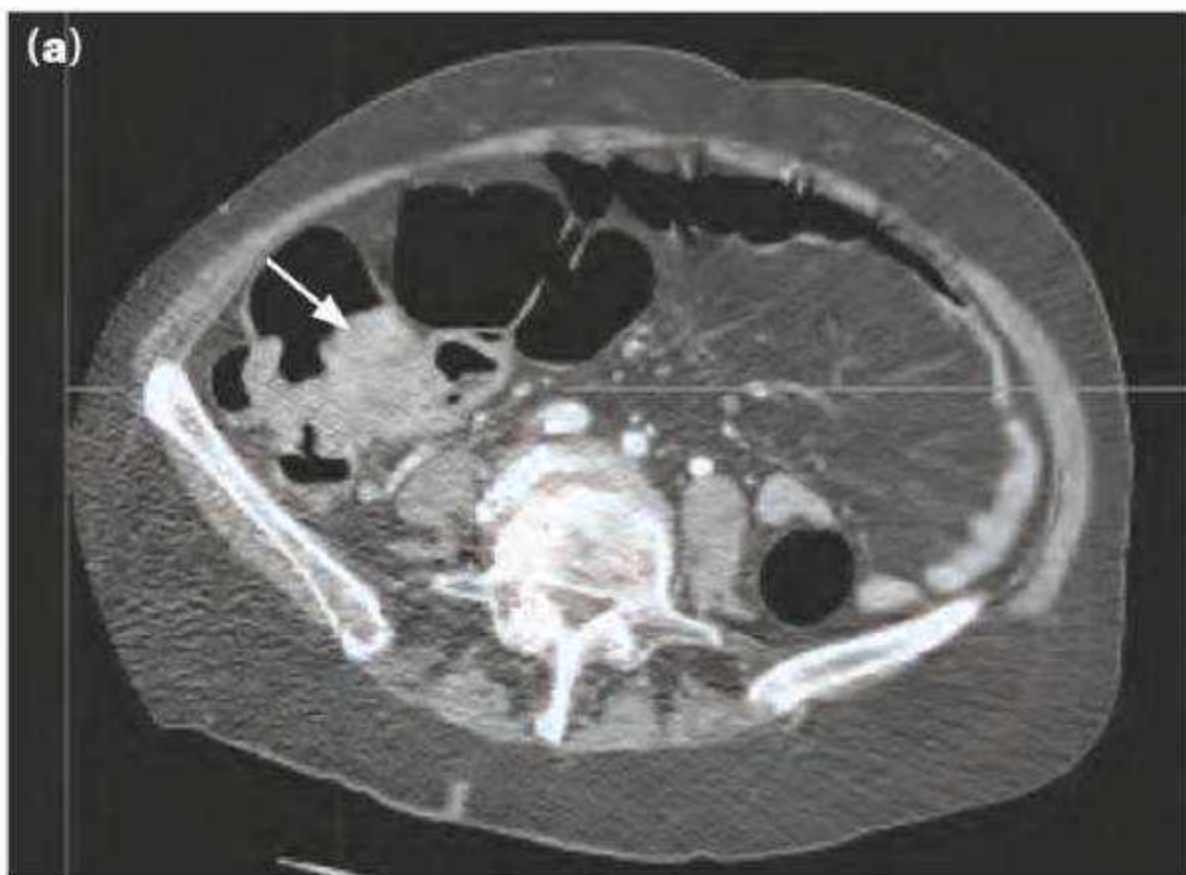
Virtual colonoscopy of the right colon. (a) Computed tomography scan of the abdomen showing a caecal tumour (arrow). (b) Formatted 'virtual' image of the same lesion as in (a) (courtesy of Dr A Slater, John Radcliffe Hospital, Oxford, UK).
